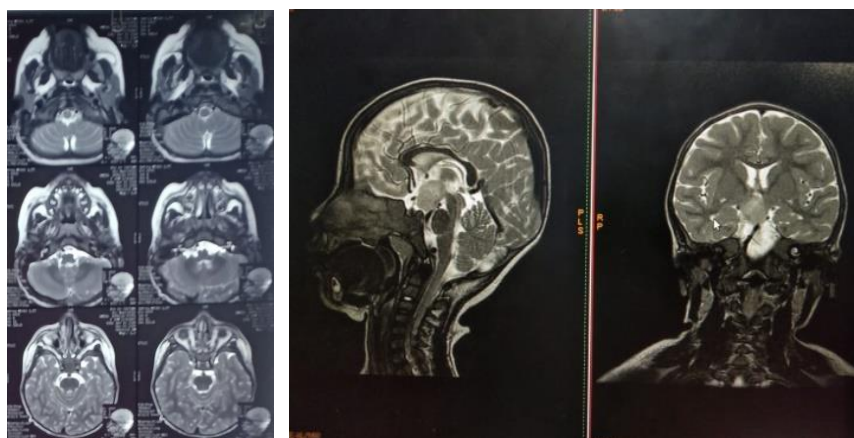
Patient's head MRI
